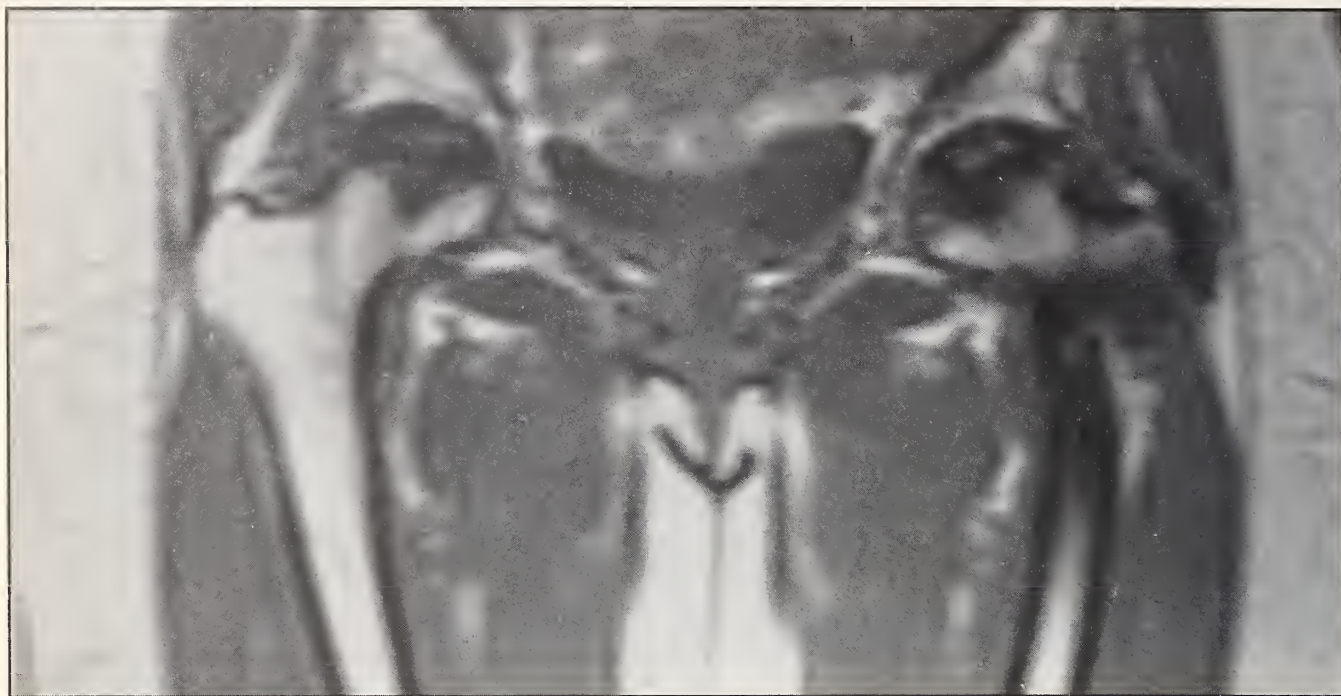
Magnetic Resonance Image highlights the areas of femoral head necrosis.
